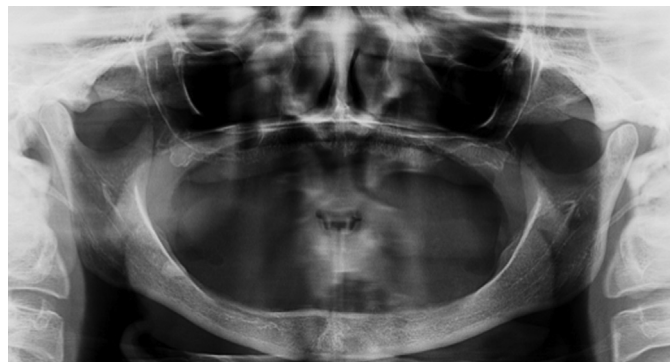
Panoramic radiograph of severely atrophic maxilla pneumatized sinuses and severe deficient bone in zones II to III of the maxilla.
